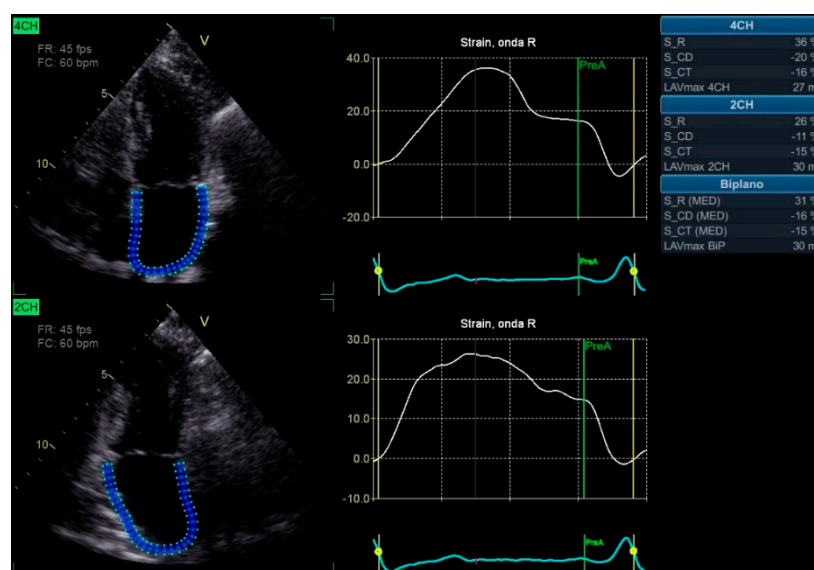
Speckle Tracking Left Atrial Strain. 2CH: apical two chambers view 4CH: apical four chambers view; LAVmax: left atrial maximum volume; S_CD: Left atrial strain in conduct phase; S_CT: Left atrial strain in contraction phase; S_R: Left atrial strain in reservoir phase.
